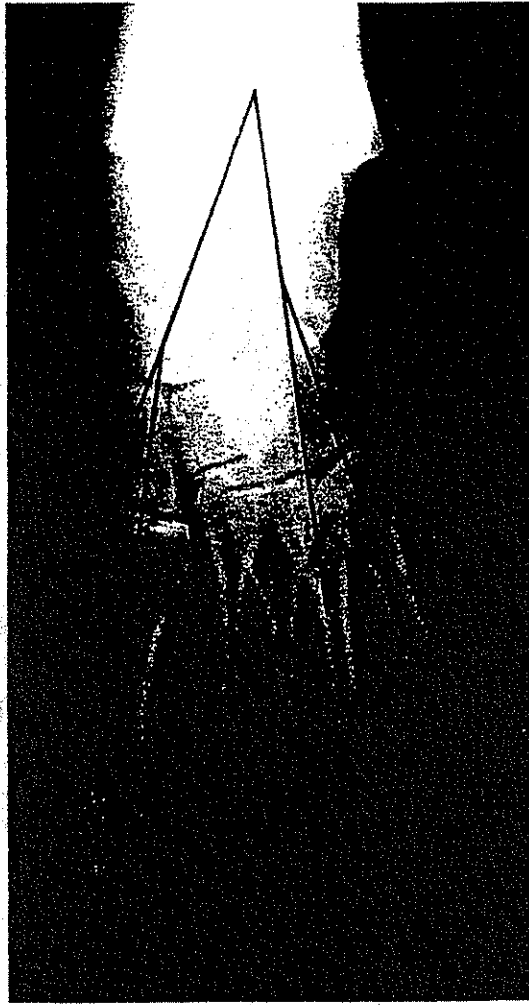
Anteroposterior roentgenogram of a clubfoot in a 20-year-old female showing the calcaneus-fifth metatarsal and talus-first metatarsal angles. These angles were used to determine the hindfoot-forefoot alignment. Both angles measure -12° , indicating mild degree of abduction of the forefoot in relation to the hindfoot. The navicular is medially displaced and is wedge shaped.
